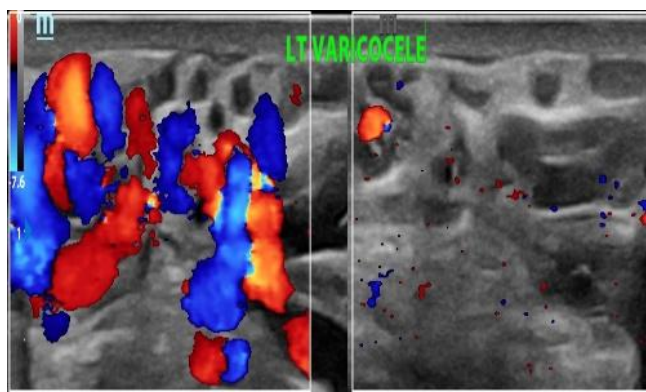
Varicocele: USG (Doppler and 2D) finding of dilated blood vessels above 2-3 mm diameter with flow reversal on Valsalva manoeuvre.
